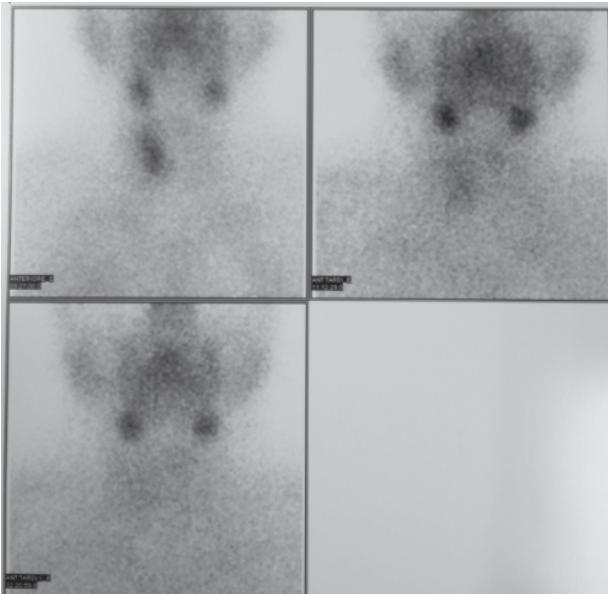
Neck scintigraphy one year after surgery.
